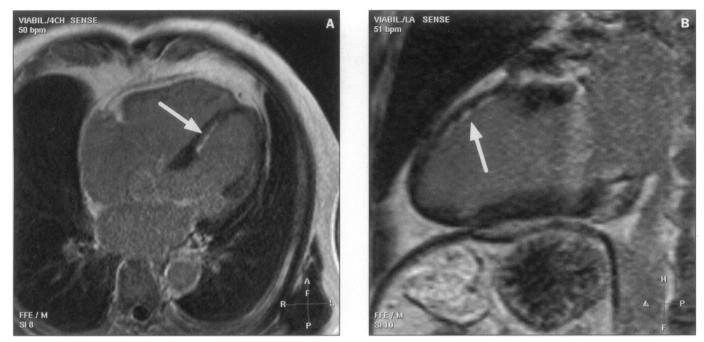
Late enhancement MRI at three months follow-up. Arrows: limited subendocardial anteroseptal infarction.
